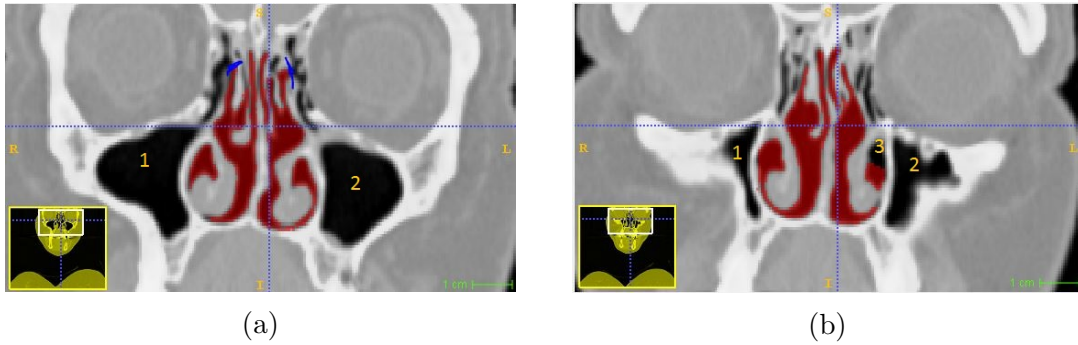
Coronal CT scan of the nasal cavity with maxillary sinuses and nasolacrimal duct marked as 1,2 and 3. The blue lines indicates the outline of the segmentation.
